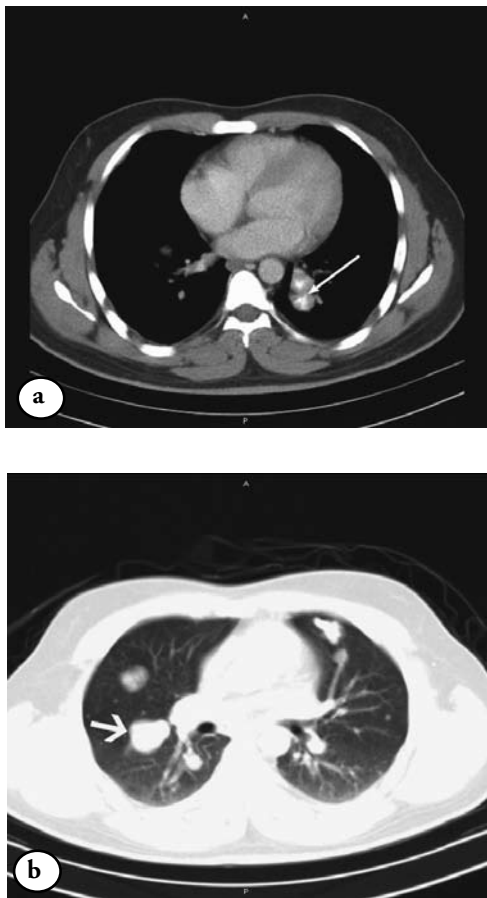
Computed tomography scan of a) chest soft tissue, and b) lung windows showing bilateral multiple lung metastatic nodules with calcifications within the nodule (arrow).
